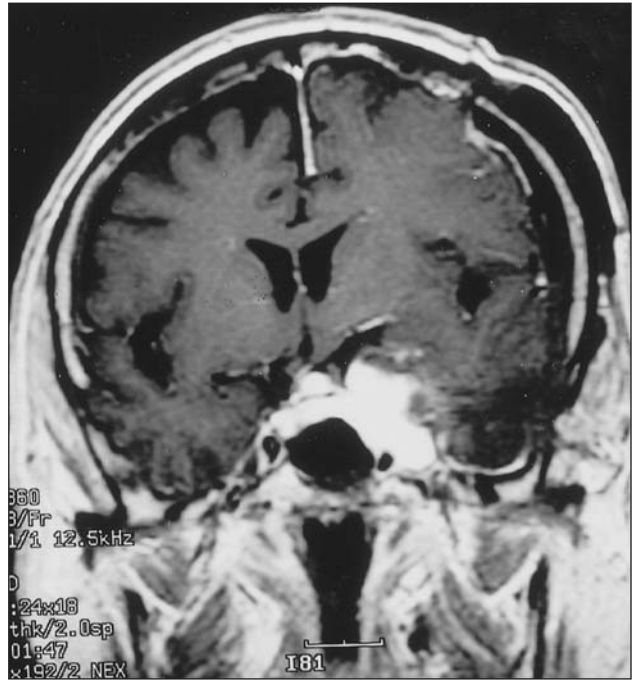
Case 1: Postoperative T1-weighted contrast coronal MRI shows residual tumoral mass on the left temporal lobe related with cavernous sinus.
